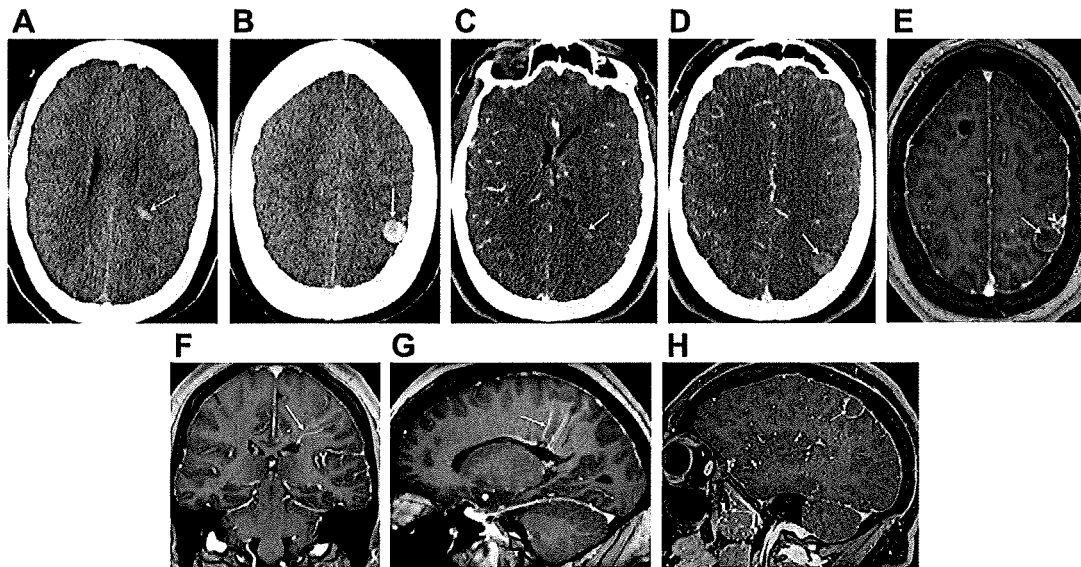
A 27-year-old woman with new-onset right-sided seizures. (A) and (B) are noncontrast axial CT images demonstrating hyperdense material (arrows) in the left parietal lobe. CT angiographic images (C, D) show that this hyperdensity corresponds to a filling defect within the main draining vein of a large left parietal developmental venous anomaly (arrow in C) and an associated venous varix (arrow in D). The filling defect is consistent with thrombus. Axial postgadolinium 3D magnetized-prepared rapid gradient echo (MP-RAGE) image (E) shows thrombus extending into a cortical vein (arrowhead) associated with the left parietal venous varix (arrow). The left parietal developmental venous anomaly (arrows) is well demonstrated on coronal and sagittal postgadolinium 3D MP-RAGE images (F, G). Postgadolinium sagittal volumetric interpolated brain examination MR venographic image (H) confirms the filling defect (arrow) in the venous varix associated with the developmental venous anomaly.
